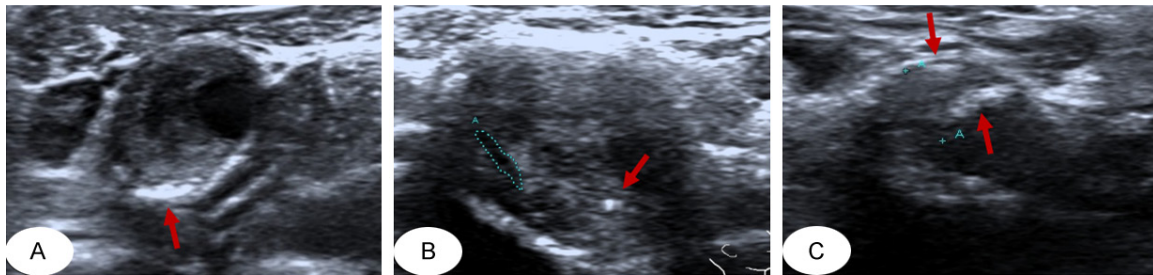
Representative two-dimensional conventional ultrasound images showing different locations of plaque calcification. A. The case is a 65-year-old man. The arrow is the coarse calcification near the basal of plaque in the left carotid artery bifurcation. B. The case is a 58-year-old man. The arrow is the coarse calcification near the intima and the streak-like calcification near the basal respectively of the plaque in the right carotid artery bifurcation. C. The case is a 73-year-old man. The arrow is the small spot calcification near the intima of plaque in the right carotid artery bifurcation.
